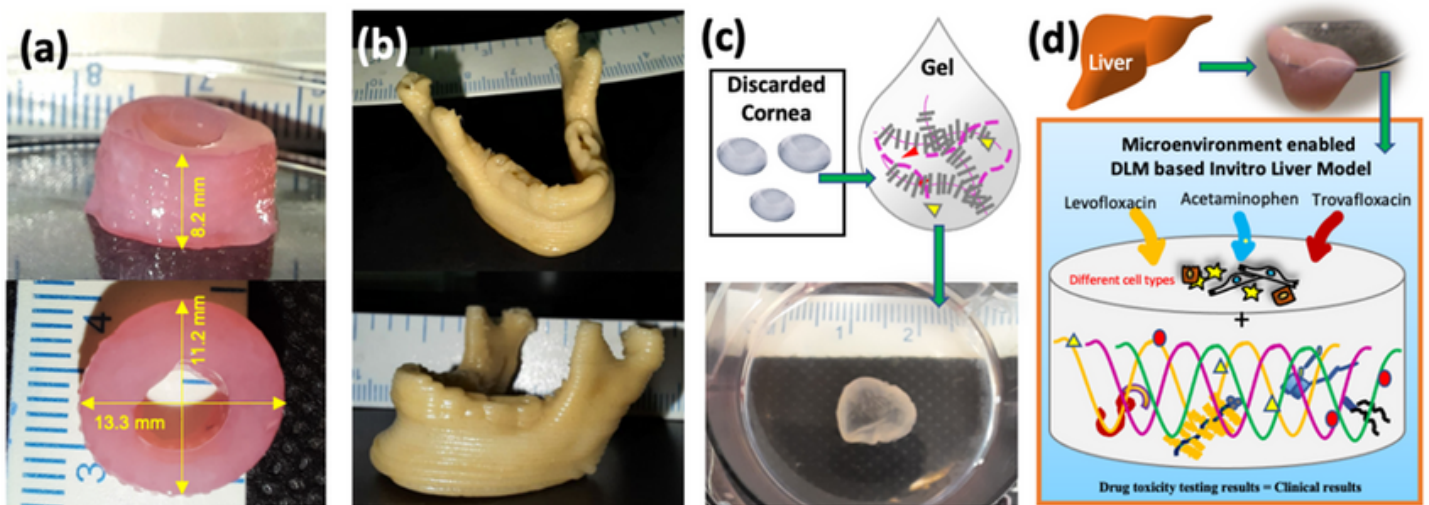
(a) 3D bioprinted tubular structure with smooth muscle matrix hydrogel for esophageal repair, (b) 3D printed patient-specific mandible from CT data for restoration of defect/damage, (c) 3D bioprinting of corneal stroma with decellularized cornea matrix hydrogel for partial keratoplasty, and (d) 3D bioprinted liver model for drug and toxicity screening
